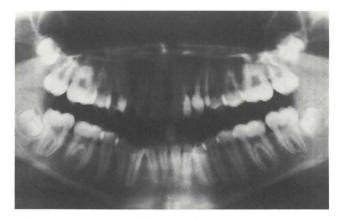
Panoramic radiograph of patient.
